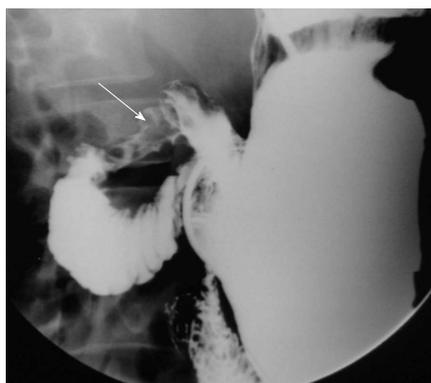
Mild luminal narrowing with ulceration is noted in the proximal duodenum. Computed tomography of this patient (not shown) revealed mural thickening of the duodenum with cystic changes suggestive of cystic dystrophy.
